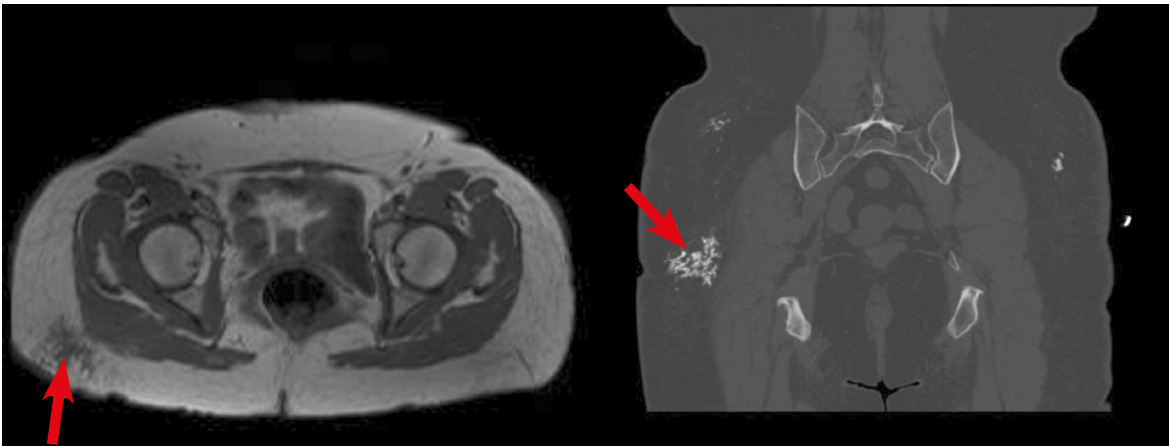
T1 weighted non-contrast MRI (left-red arrow) of dystrophic calcifications show hypointense signal in patchy patterns. These appear as calcified hazy patches on CT (right-red arrow).
